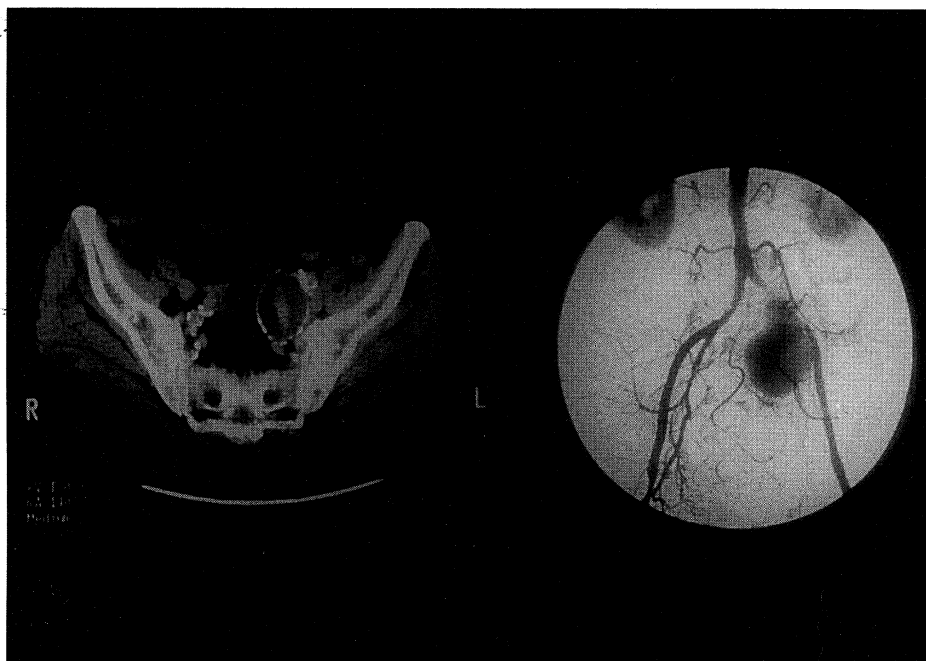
Left: Enhanced abdominal CT scan shows left common iliac artery aneurysm. Right: Preoperative arteriography shows left common iliac artery aneurysm.
